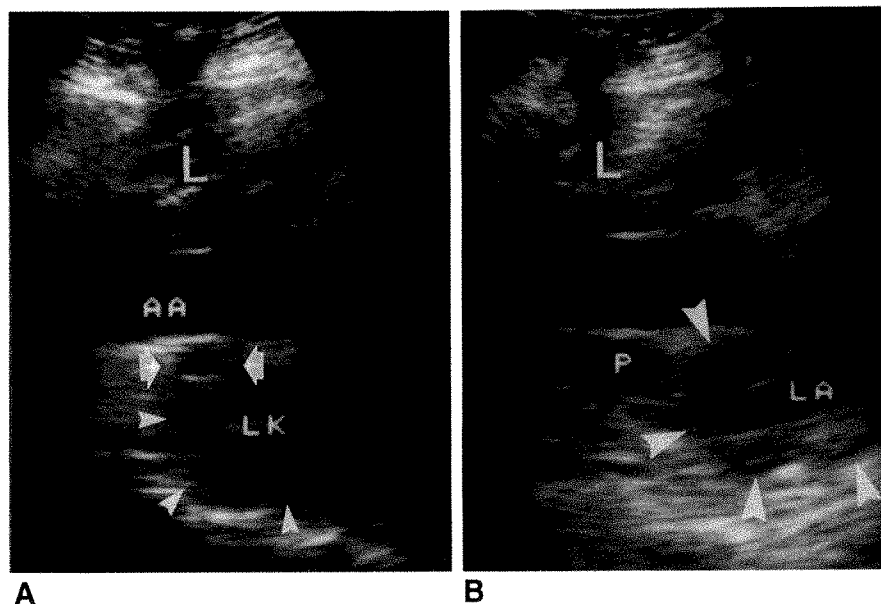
Sonograms in a 25-year-old man with incomplete remission of mediastinal lymphoma.
